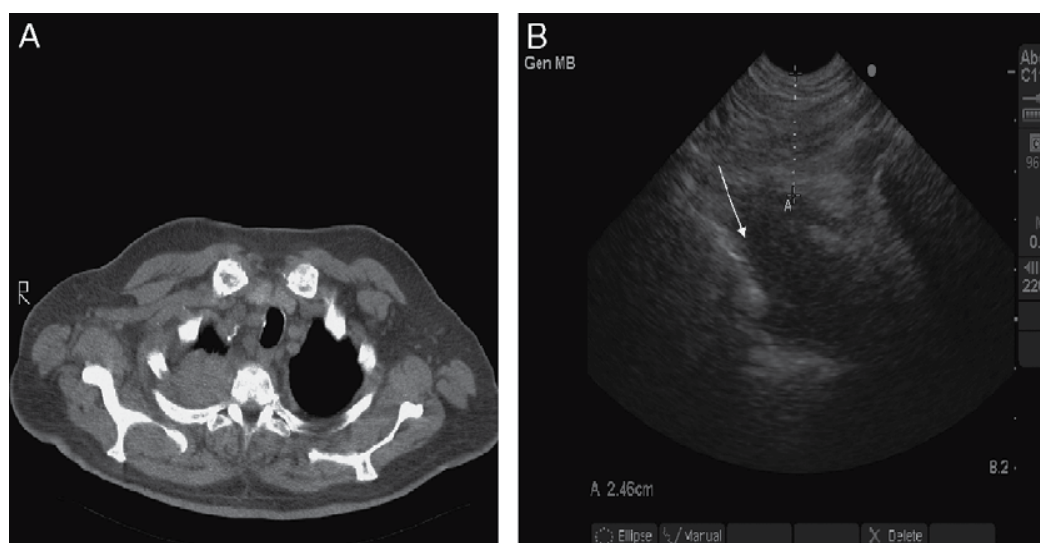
(A) Transverse computed tomography scan of the chest in a 75-year-old male smoker with right shoulder pain reveals a 4 x 5 cm pleural-based right upper lobe mass. (B) Ultrasound examination of the mass from the right supraclavicular fossa shows a hypodense mass. The mass is approximately 2.5 cm from the skin surface and is extending into the chest wall (white arrow)
